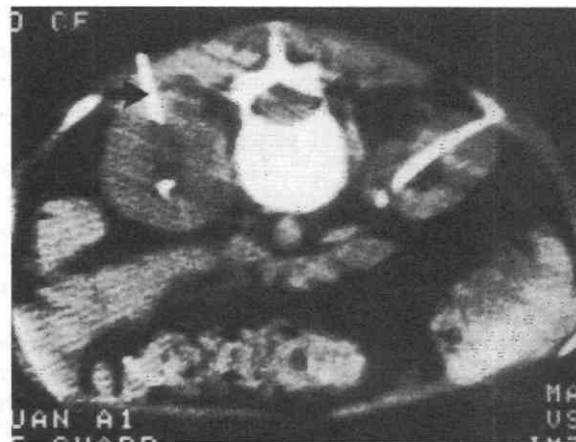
CT-guided procedure of the author's daughter (see Dedication), who had multiple renal calculi. There is one catheter in the right kidney, and this shows puncture of the left kidney with the needle (arrow). Such special cases warrant the best method available.
